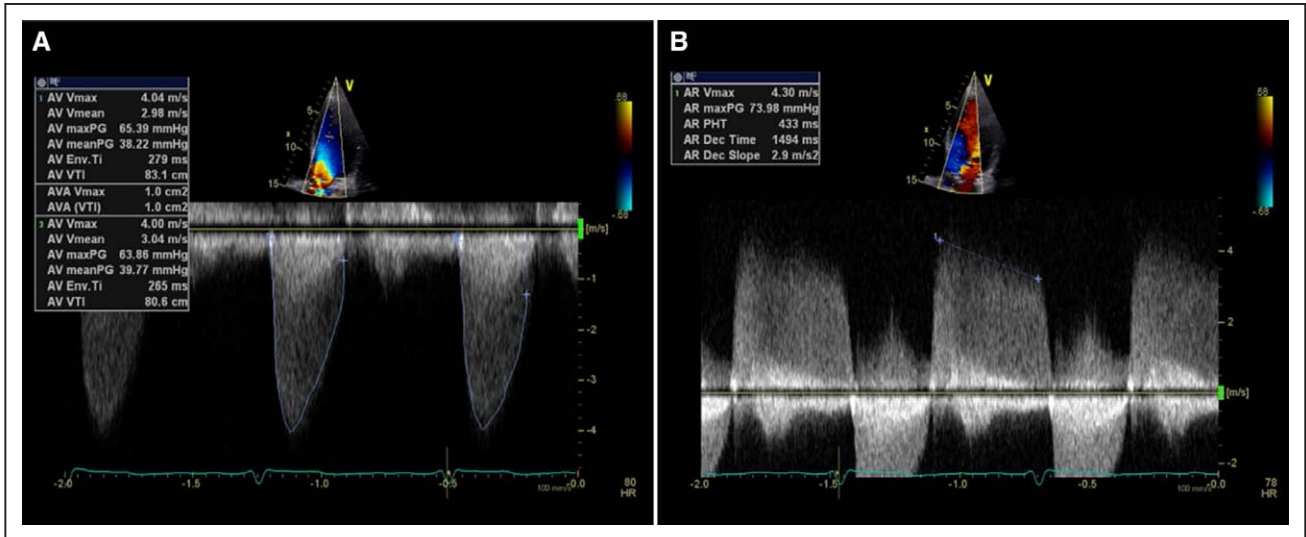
Transthoracic echo images were taken at the time of the patient's presentation to measure and assess. A, aortic stenosis and (B) aortic regurgitation. AR indicates aortic regurgitation; AV, aortic valve; PG, pressure gradient; PHT, pressure half-time; and VTI, velocity time integral.
